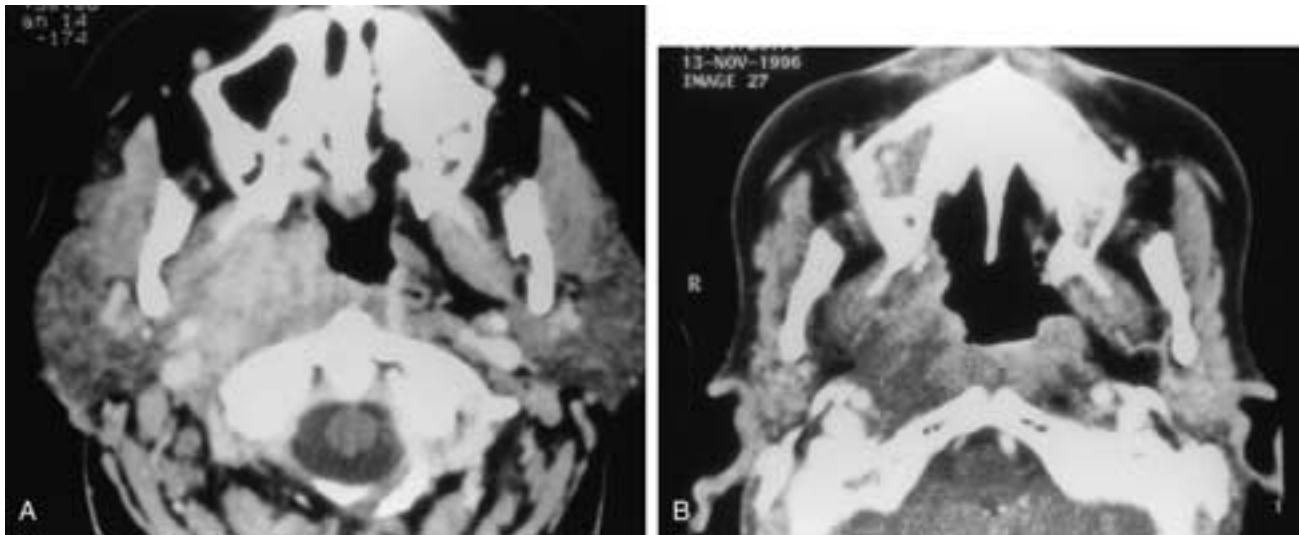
A, Axial pretreatment, contrast-enhanced CT scan demonstrates a large right tonsillar carcinoma. The mass extends laterally to involve the parapharyngeal space and invades the medial pterygoid muscle. The mass extends posteriorly to involve the carotid space. B, Following combined chemotherapy and RT, there is a marked reduction in the size and enhancement of the mass. This patient had no evidence of recurrent disease 2 years following completion of treatment.
